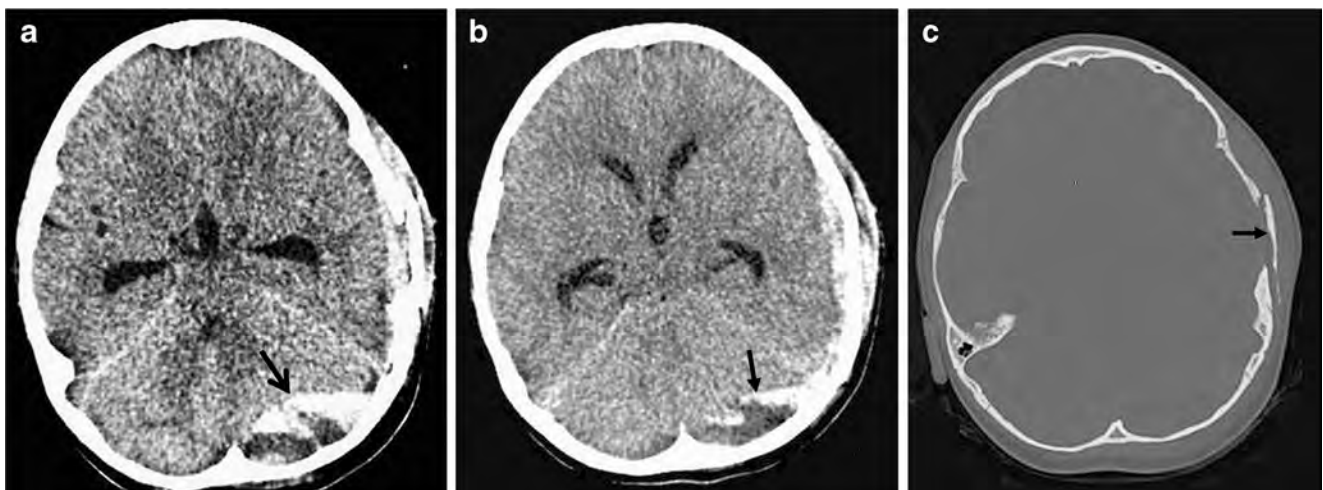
Mixed density acute subdural hemorrhage in the posterior fossa in a 18-month-old girl. a, b Axial CT image demonstrates a heterogeneous posterior fossa collection (arrows), together with a left hyperdense
